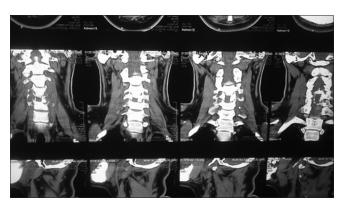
Postoperative magnetic resonance imaging showing trench coronal cuts
